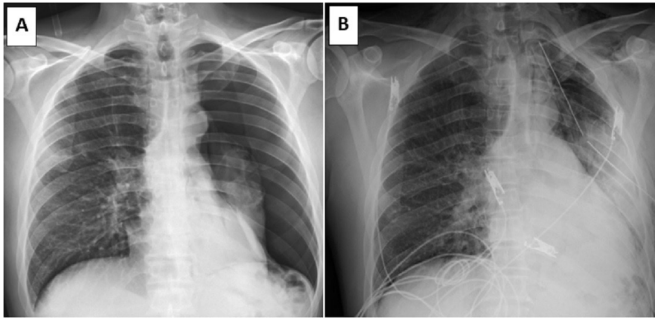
Portable chest X-ray demonstrating large left-sided pneumothorax with collapsed lung without any evidence of tension (A). Chest X-ray following chest tube insertion revealed expansion of the lung with small residual pneumothorax (B). Dense retrocardiac consolidation and mid-lung zone infiltrate were also seen.
